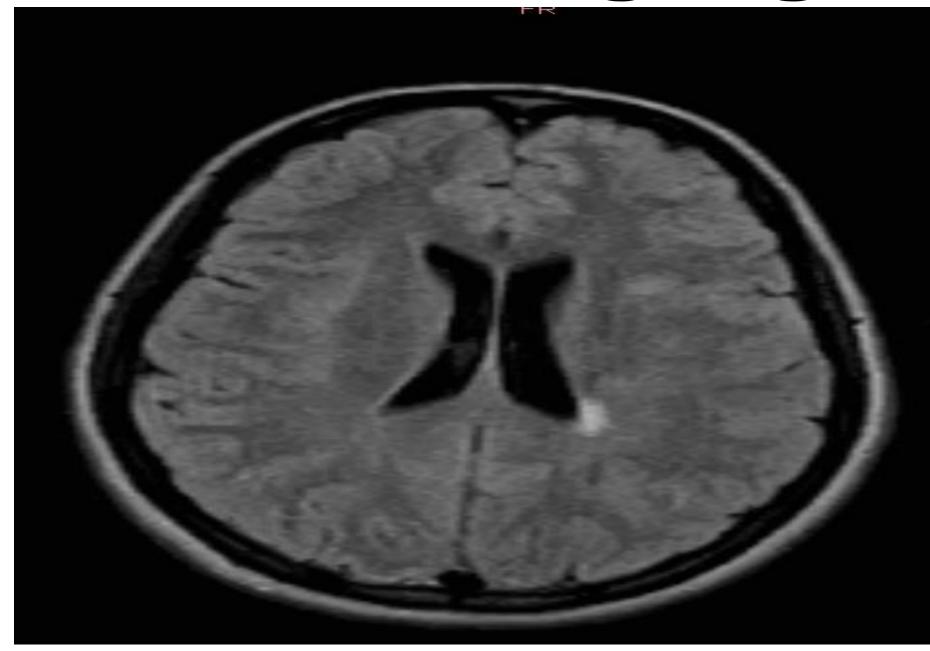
Single FLAIR lesion that suggested ADEM. 1999
